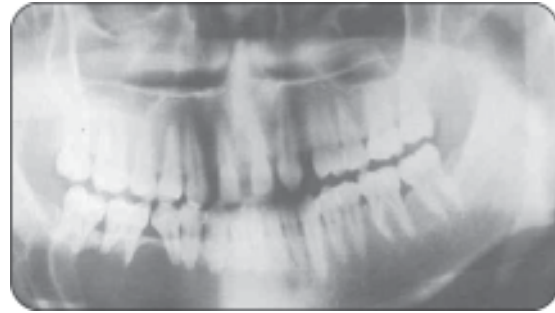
Radiograph of odontogenic keratocyst producing a multilocular radiolucent area with expansion of bone
